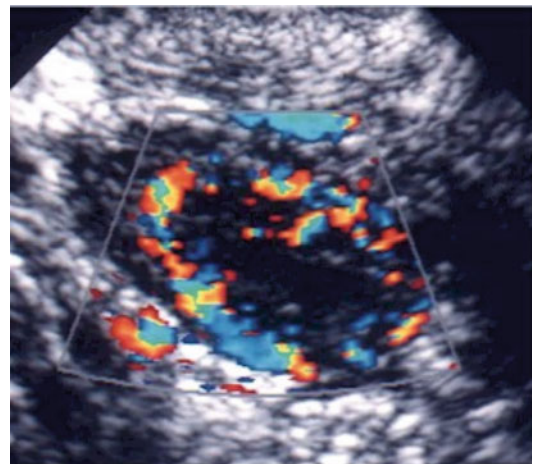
Corpus luteum ultrasound study. (1) Note the irregular cystic mass with crenulated borders and low-level echoes. (2) Doppler findings of a hypervascular corpus luteum with low resistance index
